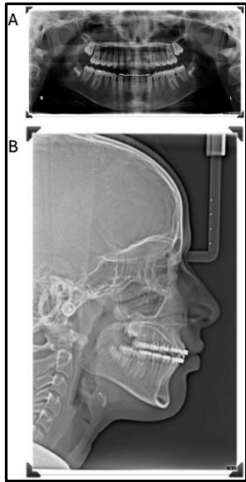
Post-treatment panoramic X-ray and near end of treatment cephalometric radiograph.
